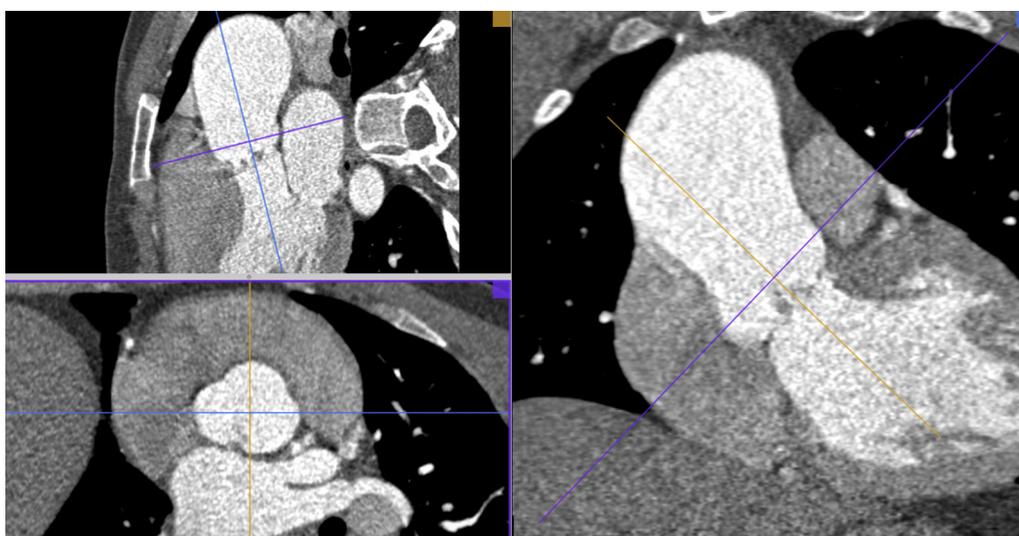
3D reconstruction of the CT angiography image with the visualization of the aortic root on a plane perpendicular to the long axis of the aorta.
